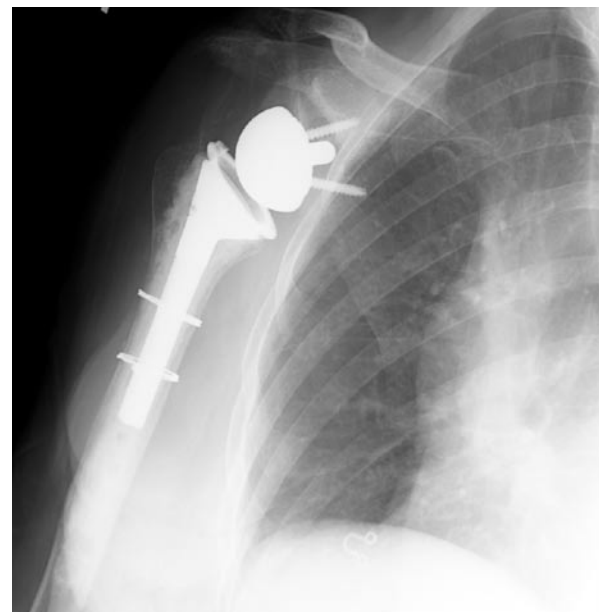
Six-week postoperative radiograph.
